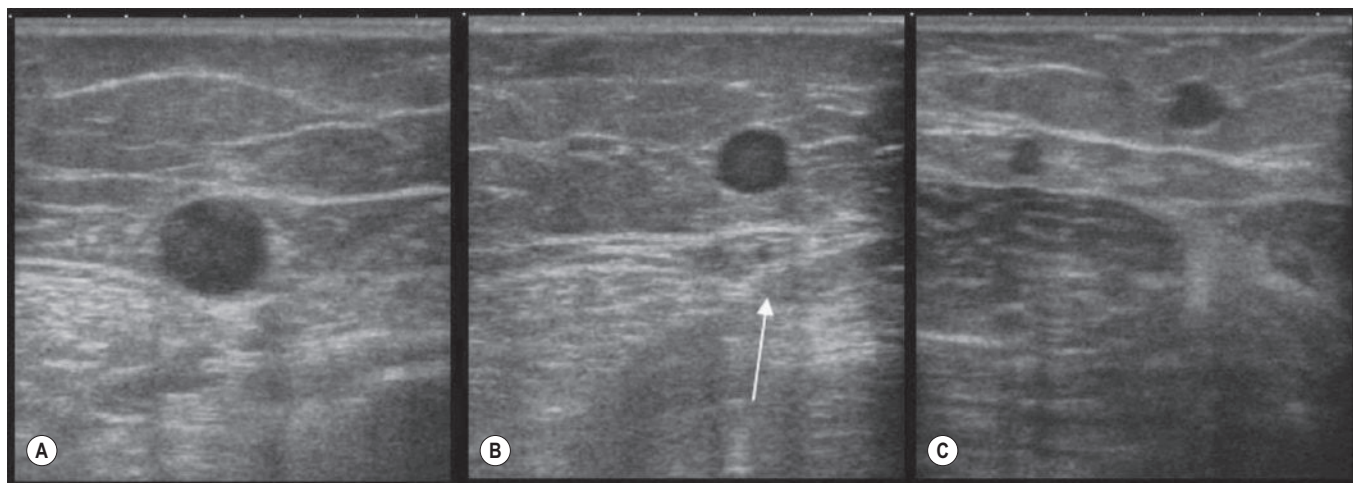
A, C, Under ultrasound, the apparent ‘eye’ that can be seen is the great saphenous vein (GSV). In B the prevailing vein is outside the compartment and must be classified as a tributary vein, whereas inside the compartment a hypoplastic GSV may be recognized (arrow). In C two veins are visible but only the one inside the compartment is the GSV.
